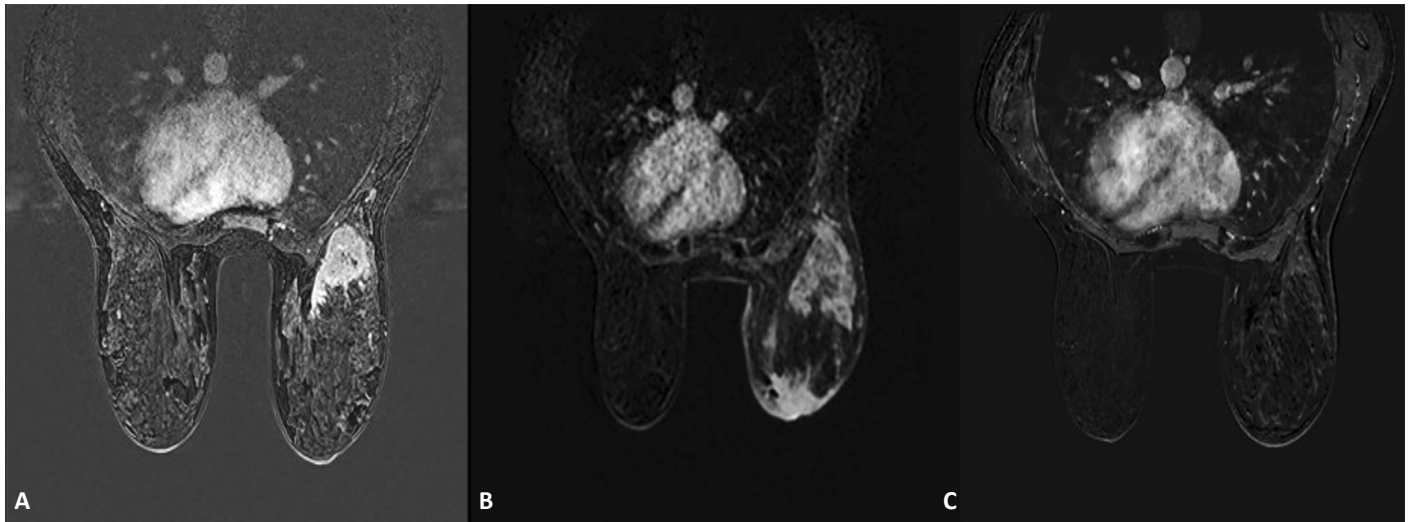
Serial breast MRI images demonstrate the radiological course of a HER2-positive malignant lesion in the right breast. At baseline (A), a malignant mass is observed in the upper outer quadrant of the right breast. At the 3-month follow-up (B), MRI reveals findings consistent with disease progression. Following the addition of anti-HER2 therapy (C), subsequent imaging shows a near-complete radiological response. HER2: Human epidermal growth factor receptor 2, MRI: Magnetic resonance imaging
